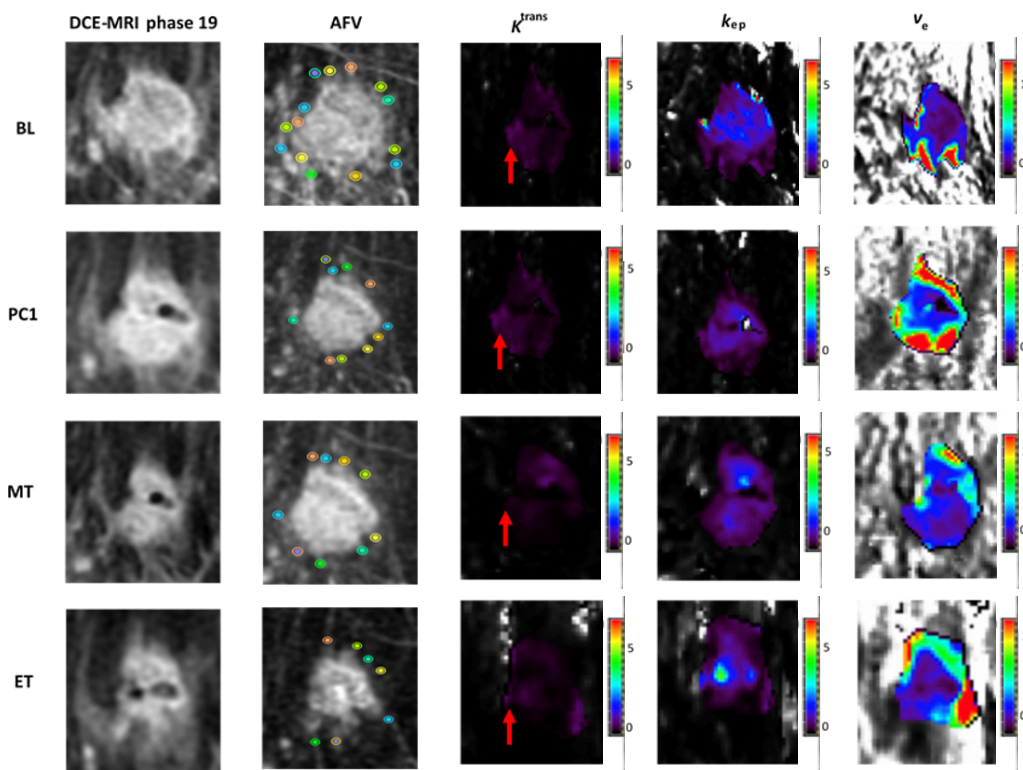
62-year-old female patient presenting with a HR-/HER2+, grade 3 breast carcinoma of no specific type (NST). Red arrows on K^{trans} maps indicate the area of the tumour that depicted the highest K^{trans} at baseline (in this area K^{trans} decreased during the course of NAC). The patient showed pathological partial response (pPR) after surgery and radiological stable disease after neoadjuvant chemotherapy (NAC). Patient treatment involved the administration of taxanes and Herceptin for 3 cycles, followed by anthracyclines for another 3 cycles (6 cycles of treatment in total). The cancer is shown at four time points during NAC: baseline (BL), post cycle 1 (PC1), mid-treatment (MT) and at the end of treatment (ET). *Left to right*: DCE-MR image at peak enhancement (phase 19); maximum intensity projection (MIP) image depicting the tumour adjacent feeding vessels (AFV); K^{trans} , k_{ep} and v_e maps of the lesion.
